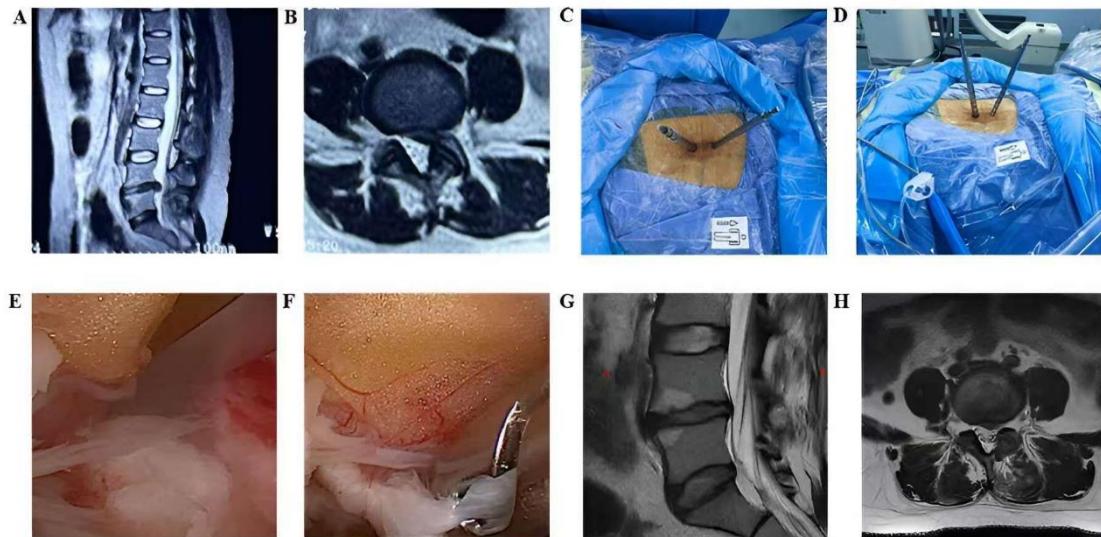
A 31-year-old female patient presented with cramping pain in the left lower limb for 9 months and numbness for 4 months. (A-B) Lumbar spine MR scans revealed paracentral disc herniation at the left L4-5 level, compressing the dural sac. (C-D) The L4-5 intervertebral space was located, and sequential dilators were used to separate the muscles. (E-F) The herniated intervertebral disc was exposed, and the nucleus pulposus tissue was removed with nucleus pulposus forceps. (G-H) Postoperative lumbar spine MR image showing that the herniated disc had been removed.
